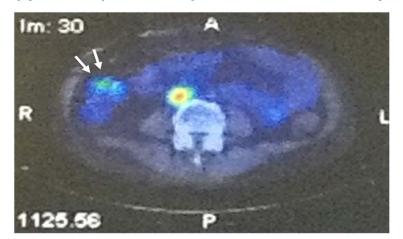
Technetium-99m-labelled human serum albumin scintigraphy showing a leak from the transverse colon (arrows)
